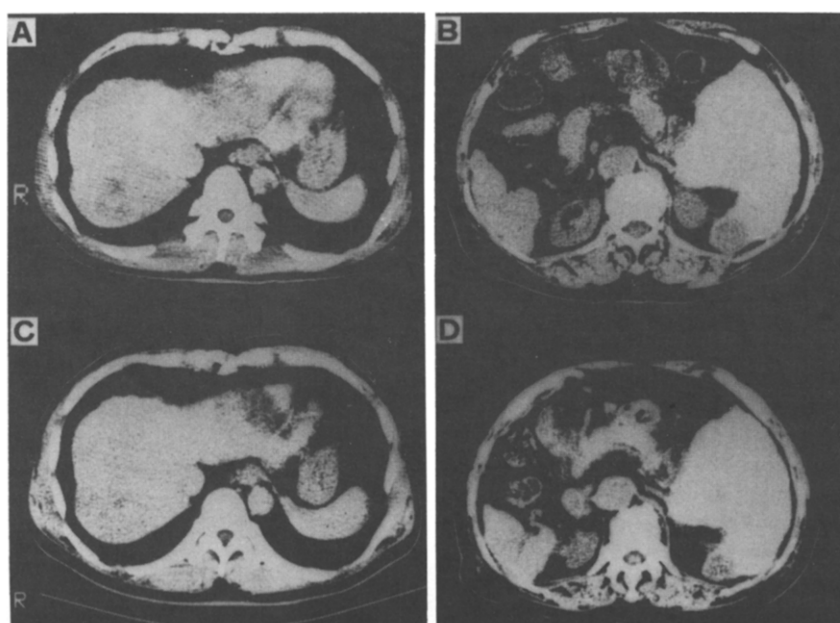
CT before (A,B) and after (C,D) treatment with rIL-2 in cases 3 and 5, respectively. Scan shows significant regression of low density area (cancer) 2 weeks after treatment.
